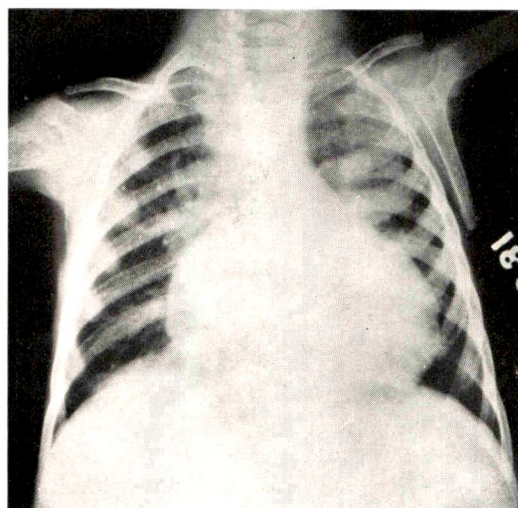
Case 1. Roentgenogram showing bronchopneumonia, pulmonary exudate; trabeculation of clavicles and scapulae, and globular heart.
